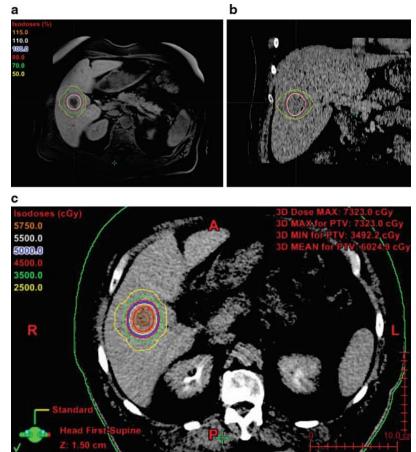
Typical radiation dose distribution for SBRT of liver metastases superimposed onto representative axial and coronal CT slices (b and c) as well as a coregistered axial MRI (a). The blue, red, green, and yellow lines represent the 50 Gy (100 % of prescribed dose), 45 Gy (90 %), 35 Gy (70 %), and 25 Gy (50 %) radiation dose. Note the steep radiation dose fall off toward the surrounding normal liver, resulting in highly effective healthy liver sparing
